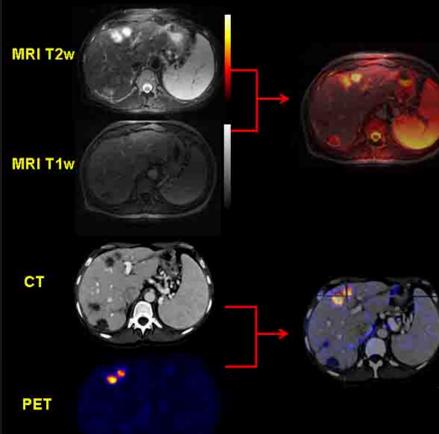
CT and MRI post initial RFA were negative. PET and CT - PET fusion diagnosed residual tumor along posterior border first.
